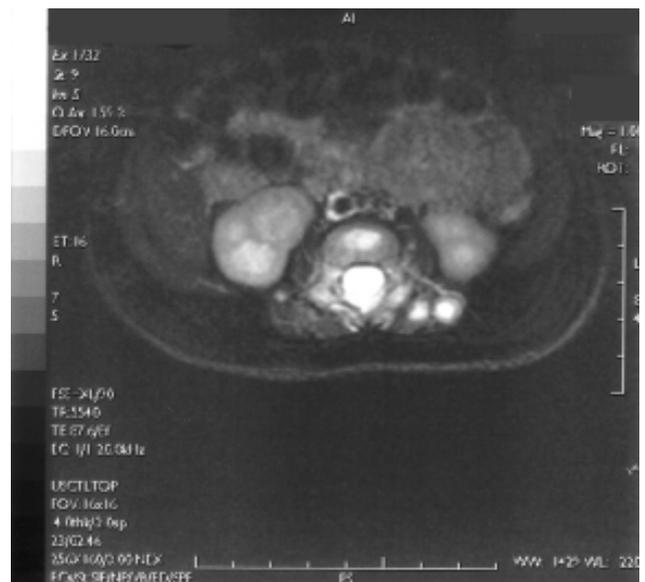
MRI spine showing ring enhancing lesions in the left erector spinae muscle.
